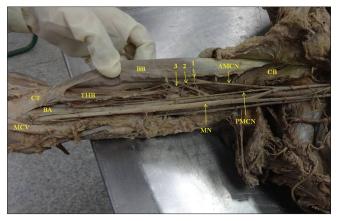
Dissection of right arm showing third head of biceps (THB) and musculocutaneous nerve dividing into anterior (AMCN) and posterior (PMCN) branches. AMCN is dividing into three branches (1, 2, 3). (BB: Biceps brachii muscle, CT: Common tendon of biceps brachii, CB: Coracobrachialis muscle, MN: Median nerve, BA: Brachial artery and MCV: Median cubital vein)
